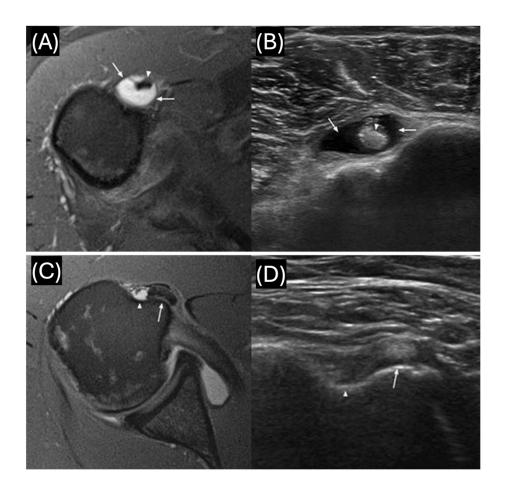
LHBT Tenosynovitis: (A) Axial T2-weighted fat-suppressed MR and (B) transverse ultrasound image reveal fluid surrounding the LHBT (arrowhead) within the biceps tendon sheath (arrows). LHBT Subluxation: (C) Axial T2-weighted fat-suppressed MR and (D) transverse ultrasound image shows the biceps tendon (arrows) medially displaced, resting on the medial rim of the bicipital groove. The bicipital groove itself (arrowhead) is devoid of the tendon [61].
